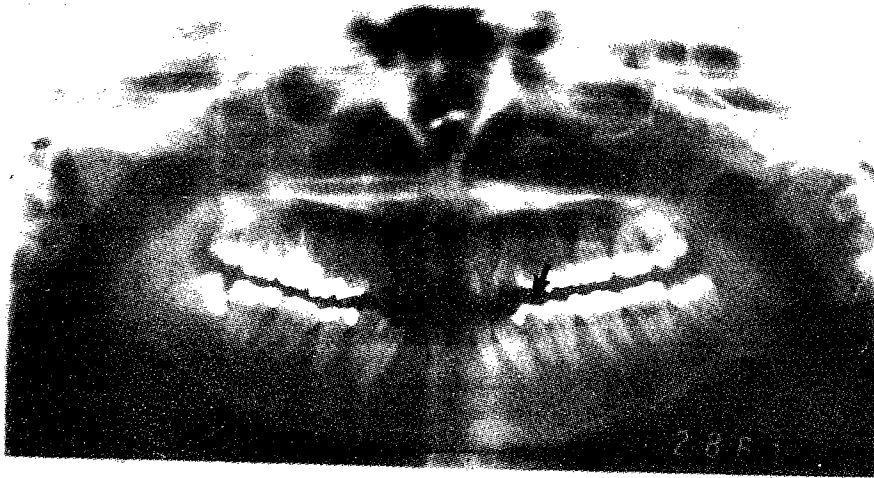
Initial panoramic radiograph. Arrow indicate extracted tooth.
